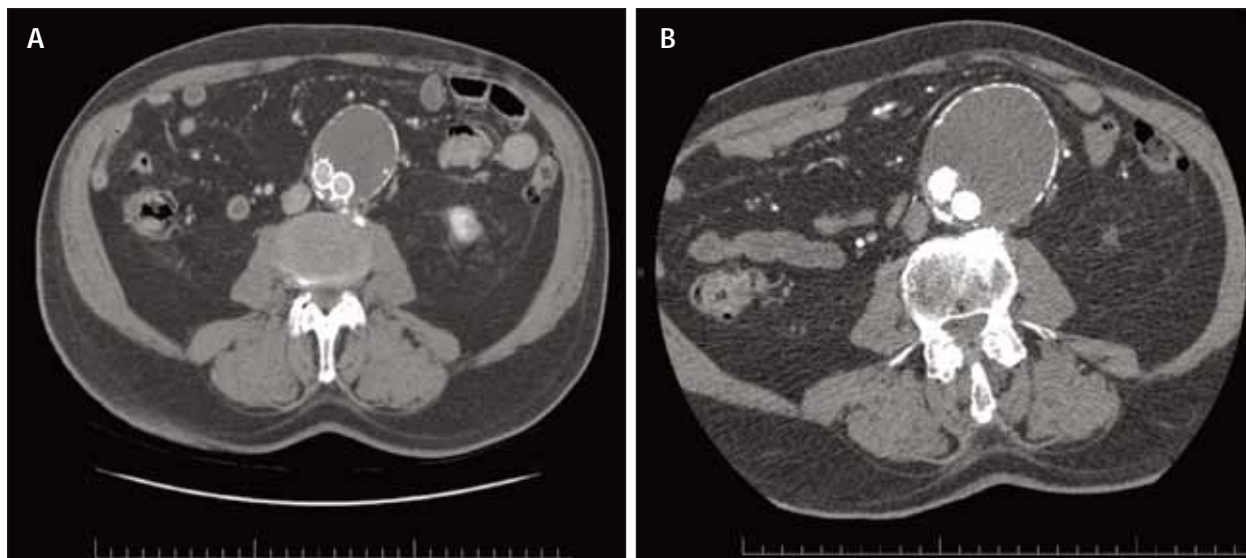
CT scans of patient demonstrating marked increase in sac size from 6 cm to 7.6 cm. Despite further imaging modalities, no endoleak was found. Given the unexplained sac increase, this patient underwent relining of the endograft with two GORE EXCLUDER® (W. L. Gore & Associates, Inc., Flagstaff, AZ) contralateral leg endoprostheses.
